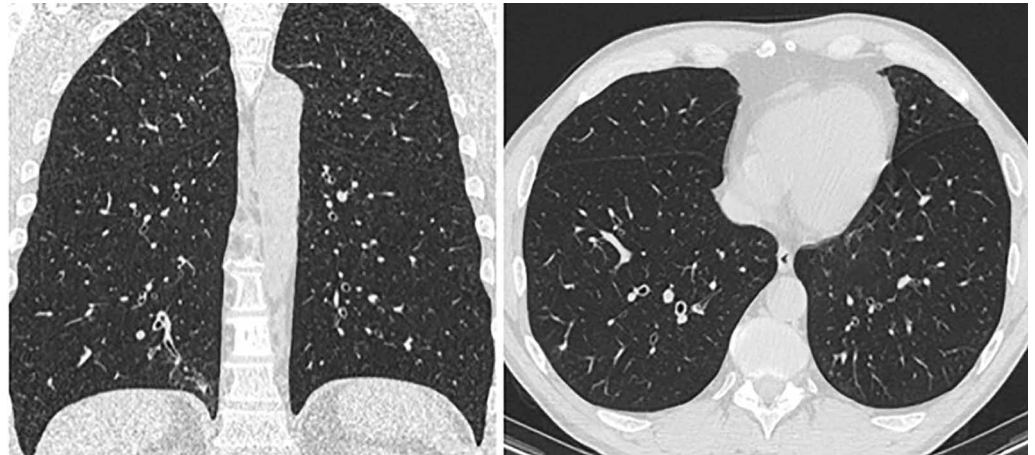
High-resolution computed tomography of the thorax.
